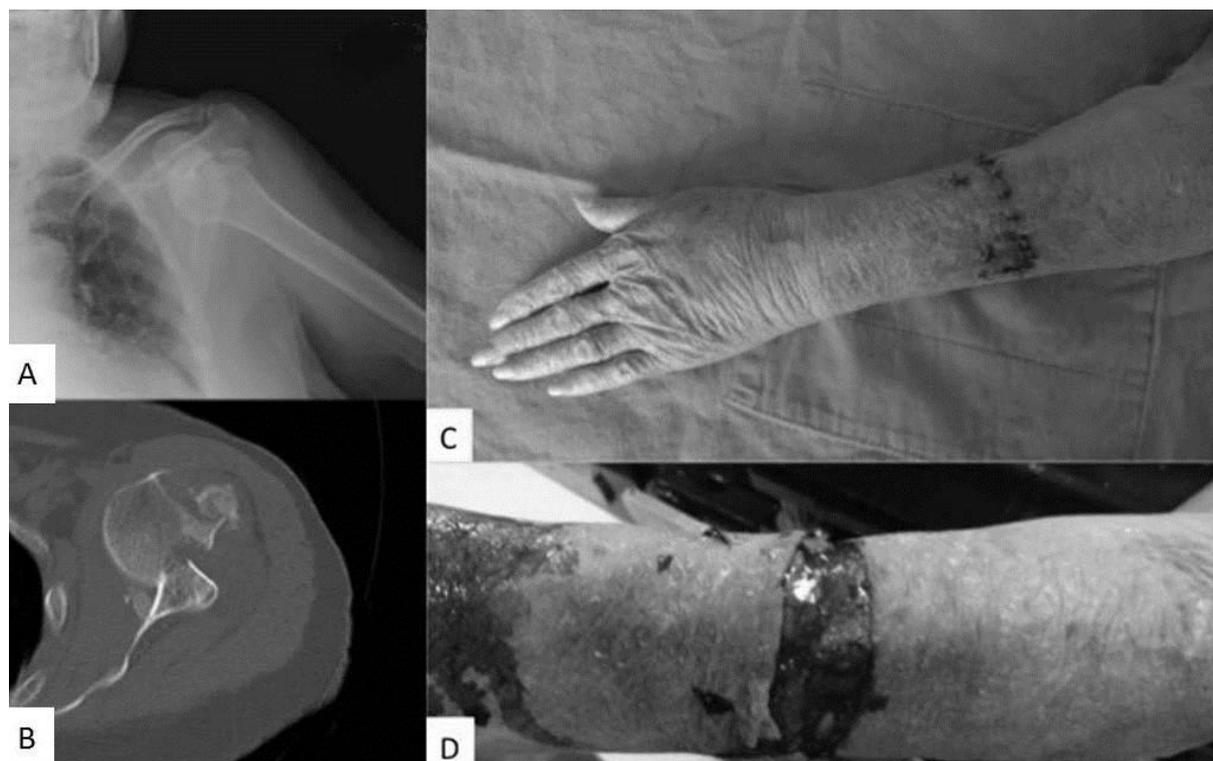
A,B: Shoulder dislocation view of patient. X-ray and CT. C: One week after the repair of the skin tear. D: Patient's forearm skin tear after the reduction of the fracture and dislocation.
